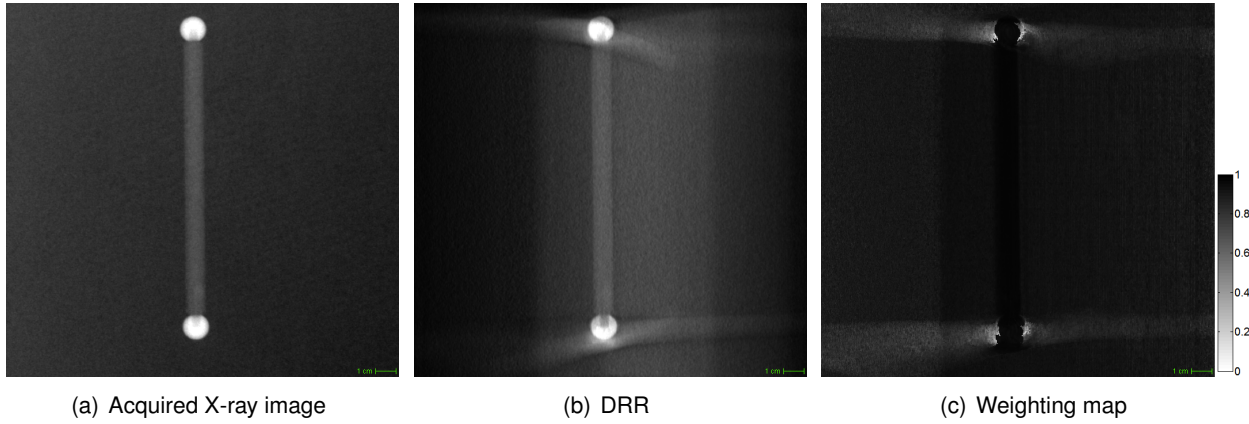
A representative X-ray image acquired with the investigated C-arm CBCT system (a). Corresponding digitally reconstructed radiograph (DRR) and projected VMR-map are shown in (b) and (c), respectively.
